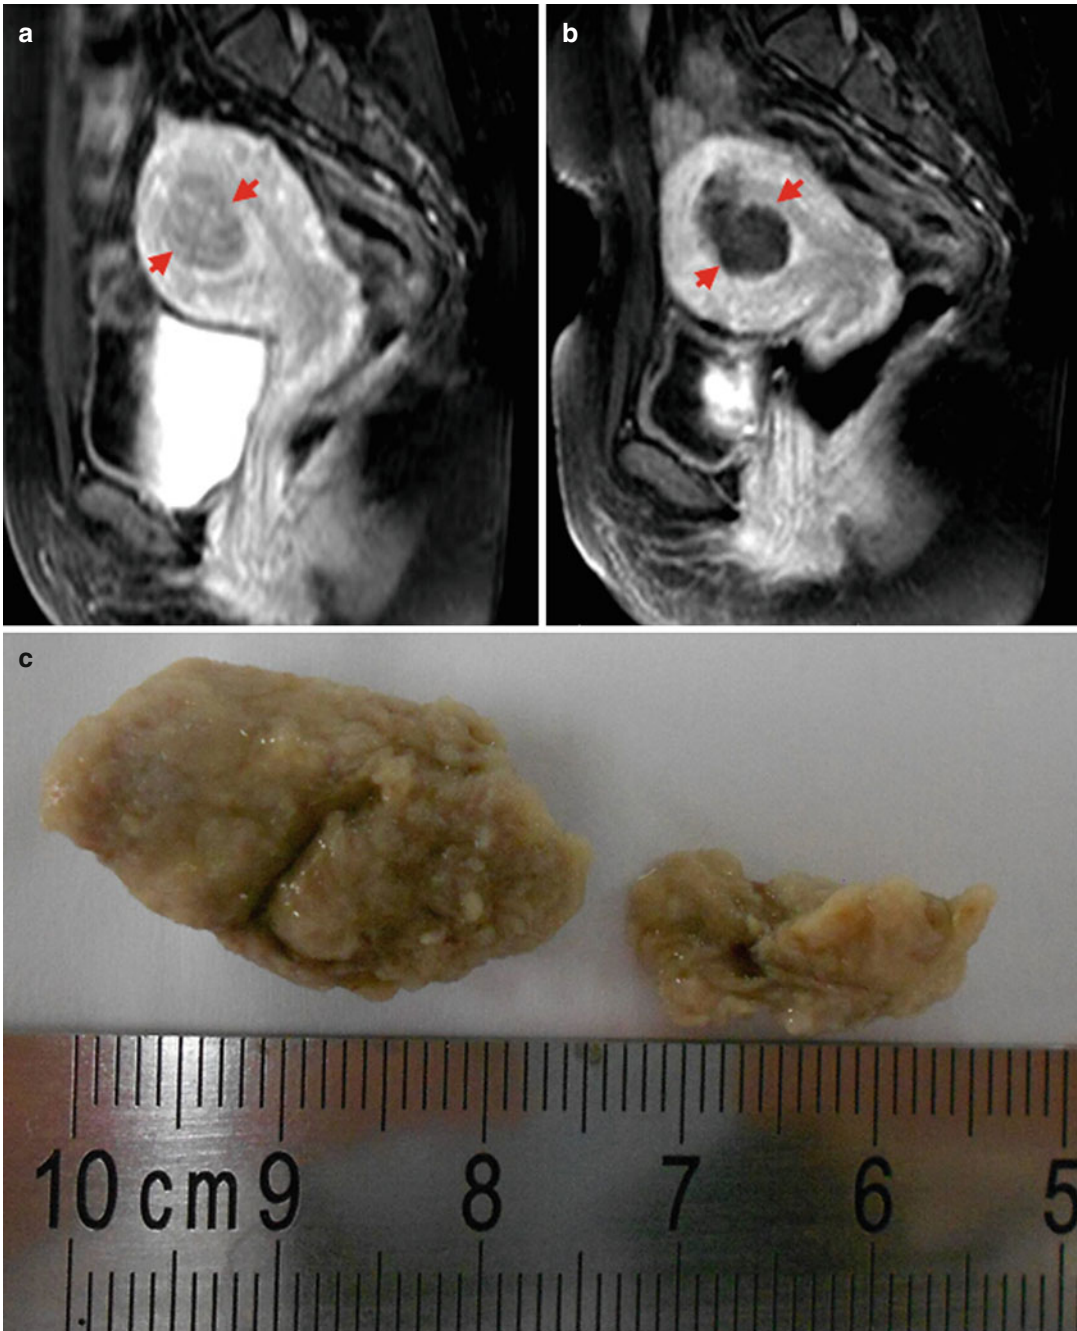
Percutaneous MWA in a 37-year-old woman with a submucosal fibroid who suffered from menorrhagia and refused hysteroscopic myomectomy. MWA was implemented to relieve her symptom. (a) Preablation sagittal T1W1 ce-MRI scan showed one enhancement submucosal fibroid (*arrows*) with the size of 3.9×3.3 cm.
